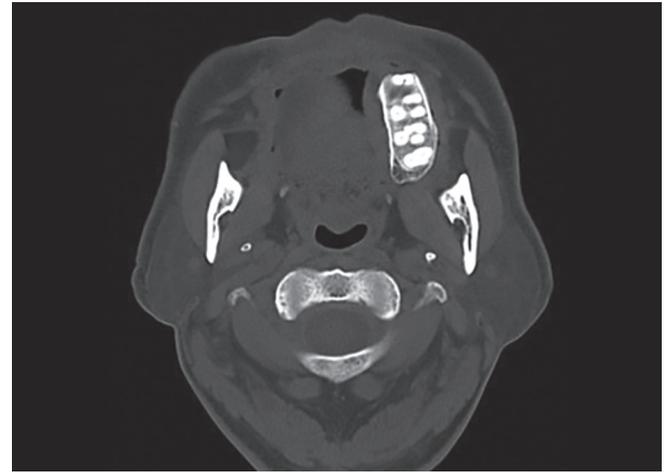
Postoperative CT scan axial view after 3 months
